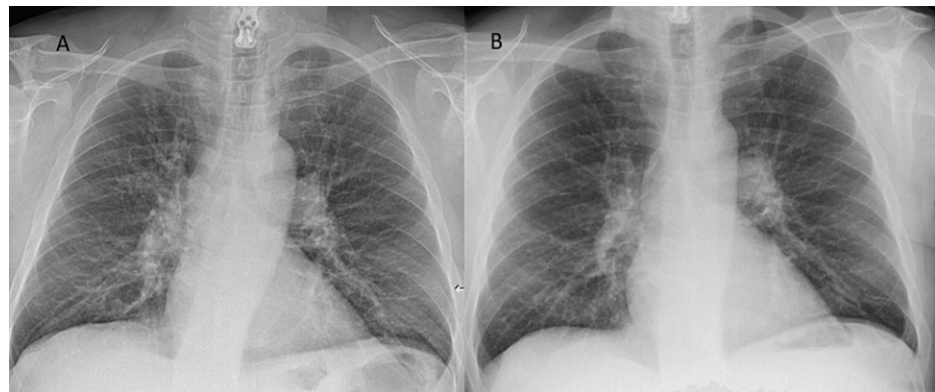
Posteroanterior chest X-rays realized for cough (a) and three years ago (b).
